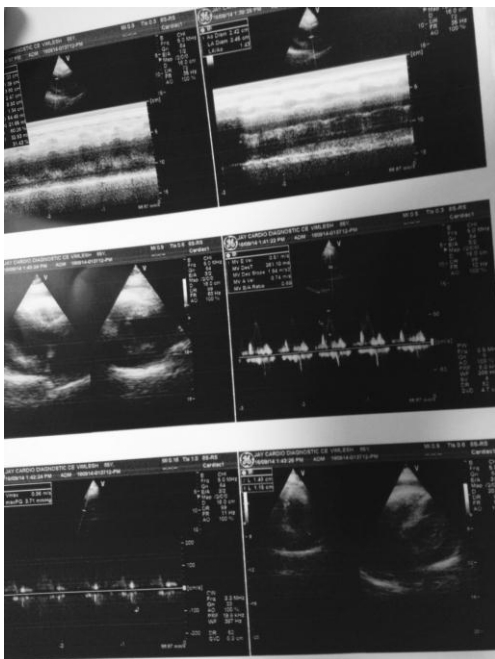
2D transthoracic echo showing moderate pericardial effusion and no intracardiac clots/vegetations.
